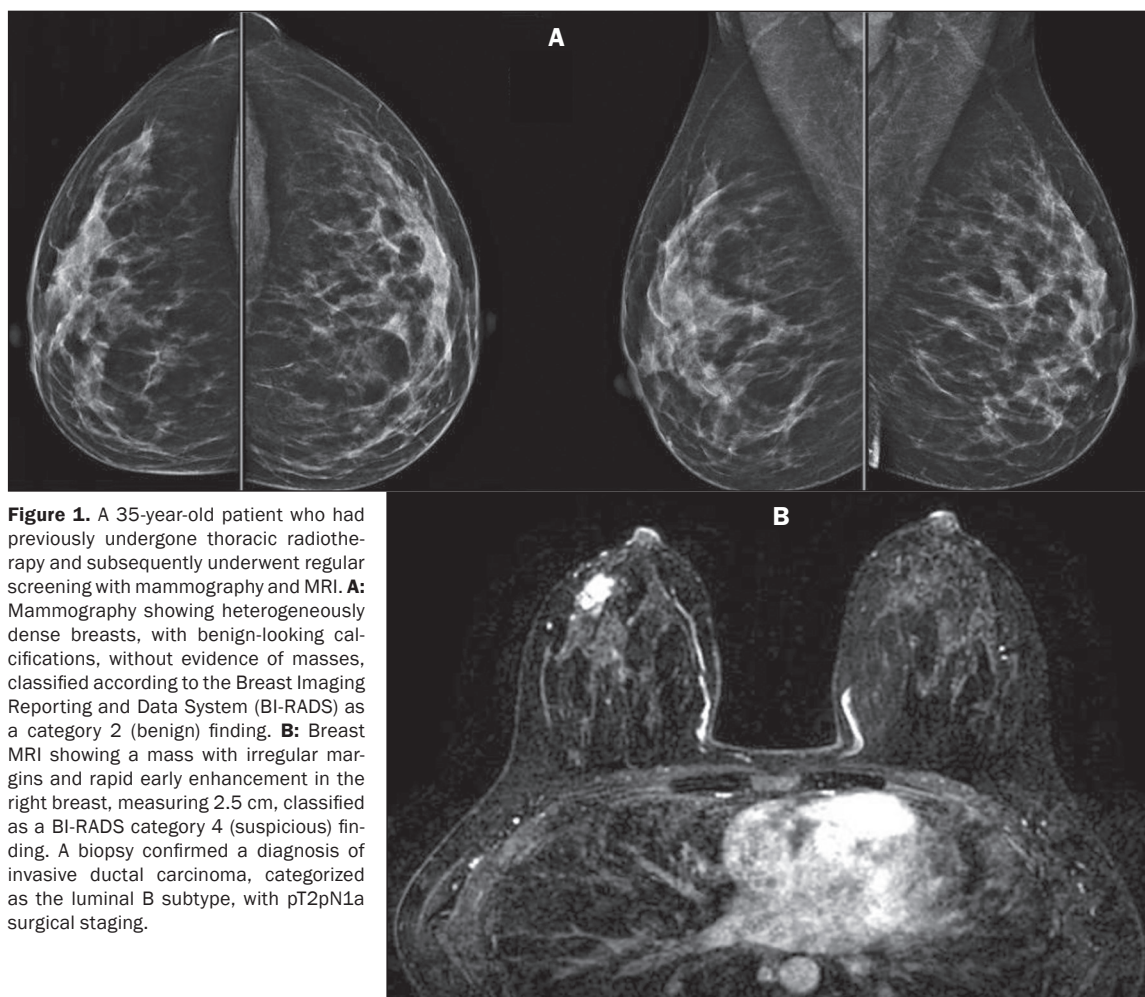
A 35-year-old patient who had previously undergone thoracic radiotherapy and subsequently underwent regular screening with mammography and MRI. A: Mammography showing heterogeneously dense breasts, with benign-looking calcifications, without evidence of masses, classified according to the Breast Imaging Reporting and Data System (BI-RADS) as a category 2 (benign) finding. B: Breast MRI showing a mass with irregular margins and rapid early enhancement in the right breast, measuring 2.5 cm, classified as a BI-RADS category 4 (suspicious) finding. A biopsy confirmed a diagnosis of invasive ductal carcinoma, categorized as the luminal B subtype, with pT2pN1a surgical staging.
